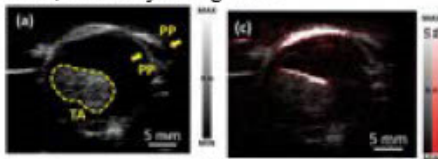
Ultrasound image vs ultrasound image overlaid with LED based photoacoustic imaging [7]
